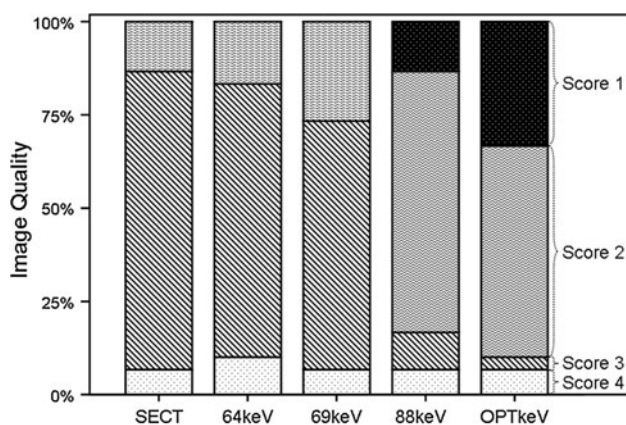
Image quality on standard single-energy CT (SECT) and monoenergetic CT reconstructions at different energy levels (64, 69, 88 keV) and at a subjectively adjusted optimal energy level (OPTkeV). Image quality was assessed using a 4-point Likert scale (score 1 excellent image quality, score 2 good image quality, score 3 limited image quality, score 4 poor image quality). Image quality improved with increasing energies of monoenergetic reconstructions at 64, 69, 88 keV, and was best at OPTkeV
